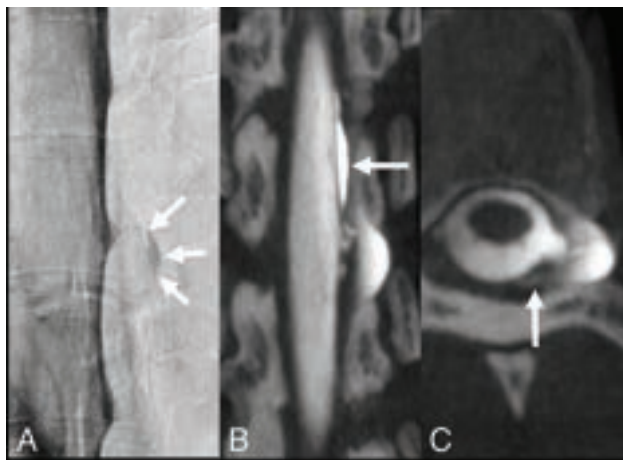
A 37-year-old woman with SIH and a persistent SLEC on MR imaging of the spine months after the epidural blood patch. Anterior-posterior DSM with the patient in the left lateral decubitus position shows a slightly contrast-filled prominent diverticulum at T7/8 (arrows in A) without extradural contrast egress. Coronal CBCT clearly demonstrates an epidural contrast collection (arrow in B) next to the diverticulum. Axial CBCT shows a type 2 leak with more posterior contrast leakage (arrow in C) (caused by encapsulation and neomembranes as reported from the operation), previously not visible on DSM due to superimpositions. CBCT settings are the following: 3D-(4sDCT Body Care), 49-cm zoom, 90 kV, 134 mA, 90 images/sec in 3.53-second runtime (248 total images).
